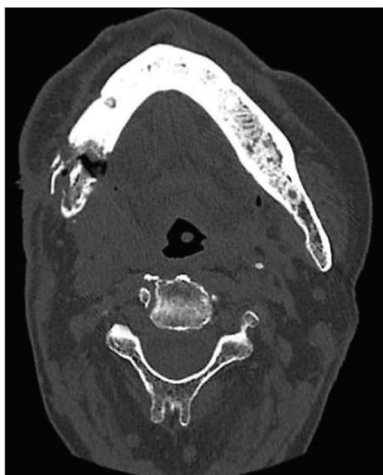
Computed tomography (CT) scan of the head; transversal view. CT scan of the face, neck and chest was performed without contrast, showing pathological fracture of right jaw and periosteal reaction, besides mixed lytic and sclerotic lesion of the jaw.
